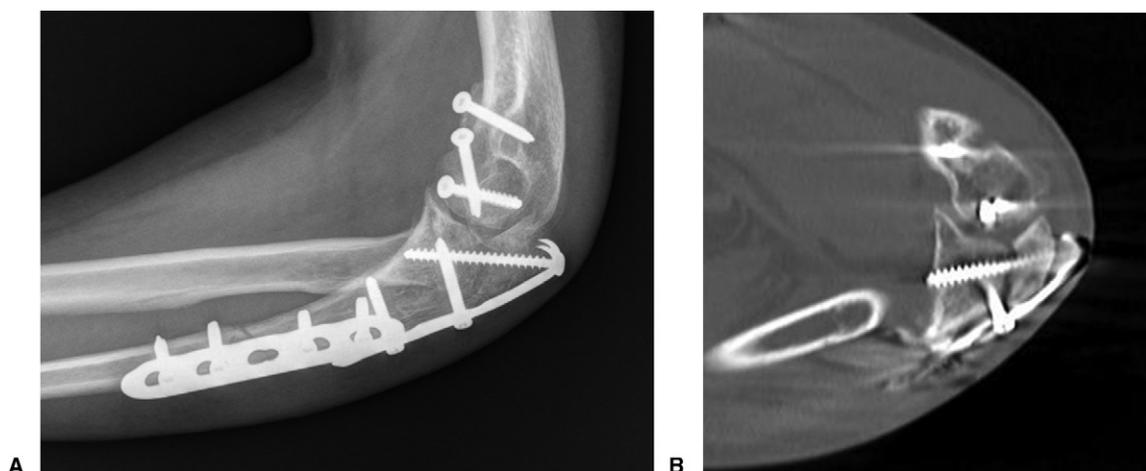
Over-compression of the articular surface resulting in malunion of the semilunar notch. A Plain radiograph; B computed tomography image.
